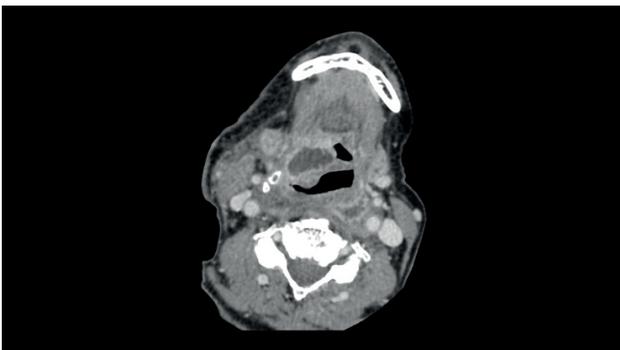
The CT scan of the neck with contrast showing increased fluid collections in the right parapharyngeal space causing the narrowing of the throat.
